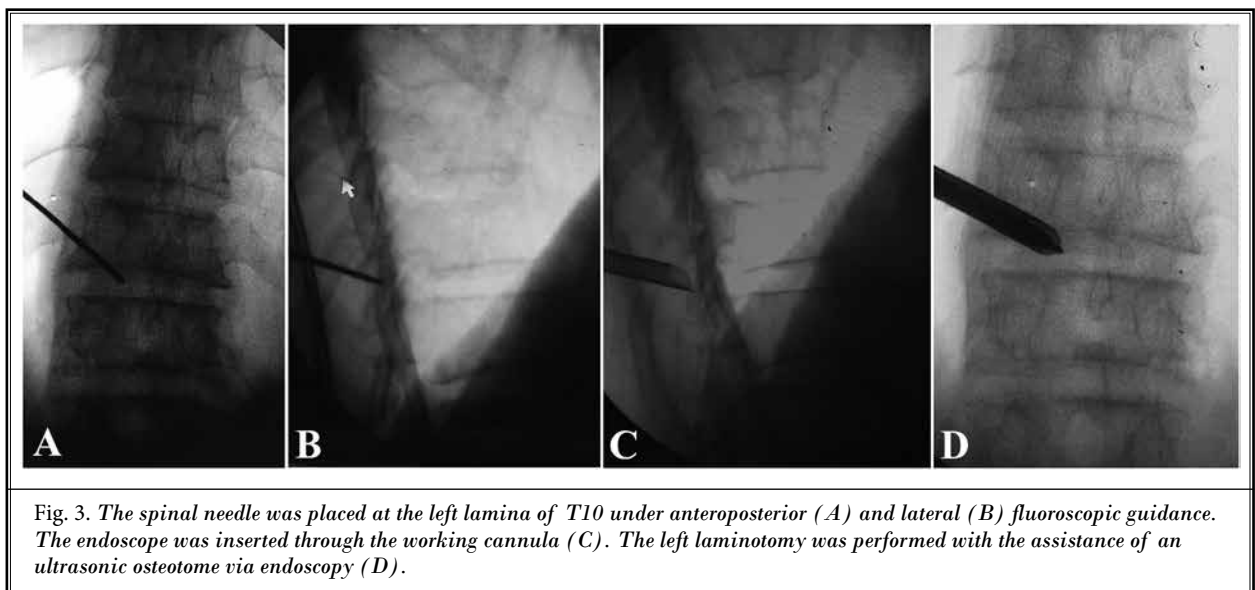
The spinal needle was placed at the left lamina of T10 under anteroposterior (A) and lateral (B) fluoroscopic guidance. The endoscope was inserted through the working cannula (C). The left laminotomy was performed with the assistance of an ultrasonic osteotome via endoscopy (D).
